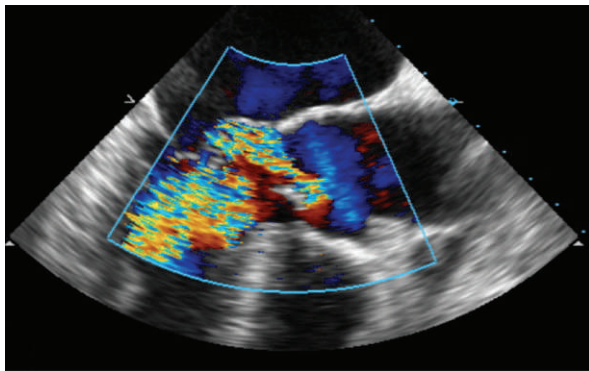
Preoperative transesophageal echocardiogram shows severe aortic regurgitation with a large, posteriorly directed jet.
